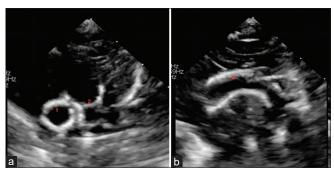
Transthoracic echocardiography (a) A parasternalshort-axis view at the great arterial level showing hyperechoic walls of the aorta and pulmonary artery showing 1: aorta, 2: the pulmonary artery with hyperechoic walls, (b) Suprasternal arch view showing hyperechoic walls of ascending aorta and arch (*)
